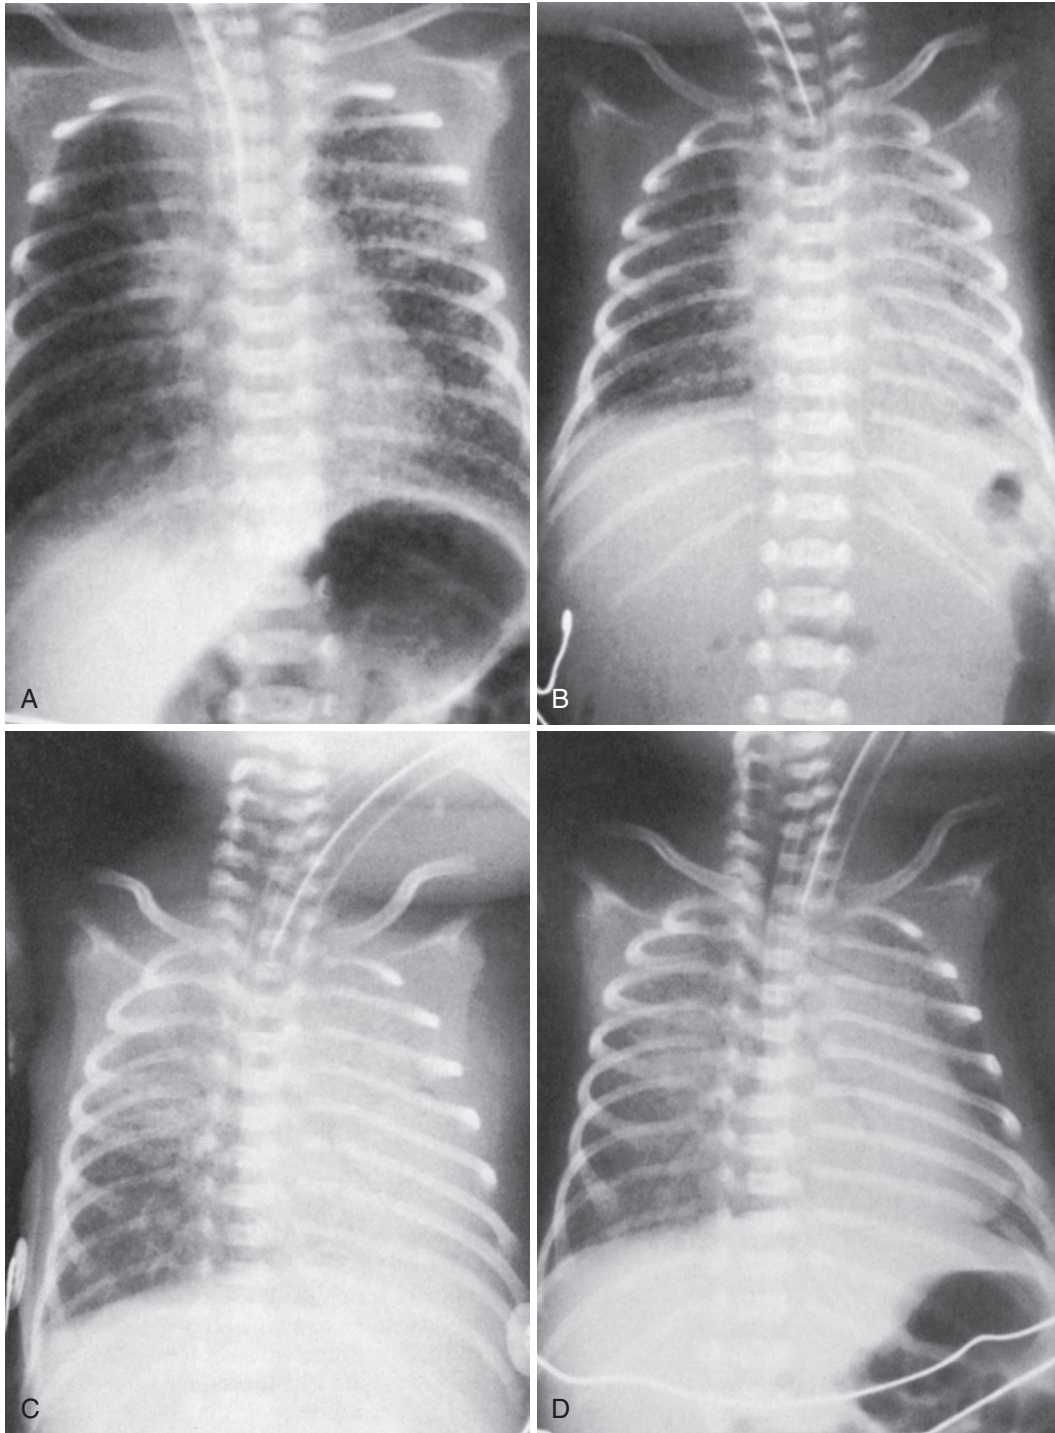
Radiographs of a 2-day-old preterm infant with pulmonary interstitial emphysema (PIE). A, mP_{aw} equal to 16 cm H_2O and F_{iO_2} equal to 0.65. B, Six hours later, mP_{aw} equal to 8 cm H_2O and F_{iO_2} equal to 1. C, Twelve hours later, settings were unchanged, PIE was resolved, and the lung was nearly totally deflated. D, Thirty-six hours later, reinflation was beginning, mP_{aw} was equal to 12 cm H_2O , and F_{iO_2} was equal to 0.45.
